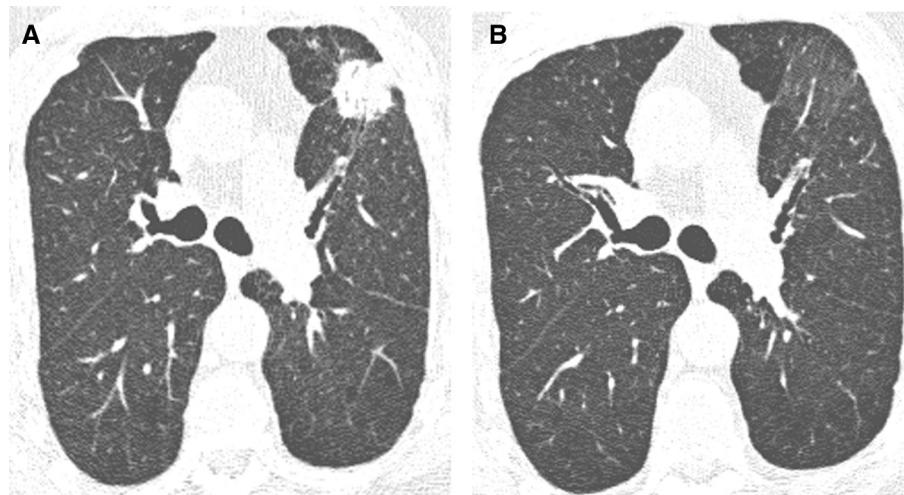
Transient solid nodule. Baseline screening computed tomography (CT) of a patient who was high risk and asymptomatic, demonstrating a 27×28 -mm solid nodule in the left upper lobe. The nodule contains air bronchograms and should be classified as Lung Reporting and Data System (LU-RADS) 3L (indeterminate; requires follow-up CT). (B) Follow-up CT 8 weeks later, demonstrating near-complete resolution (LU-RADS 1).
